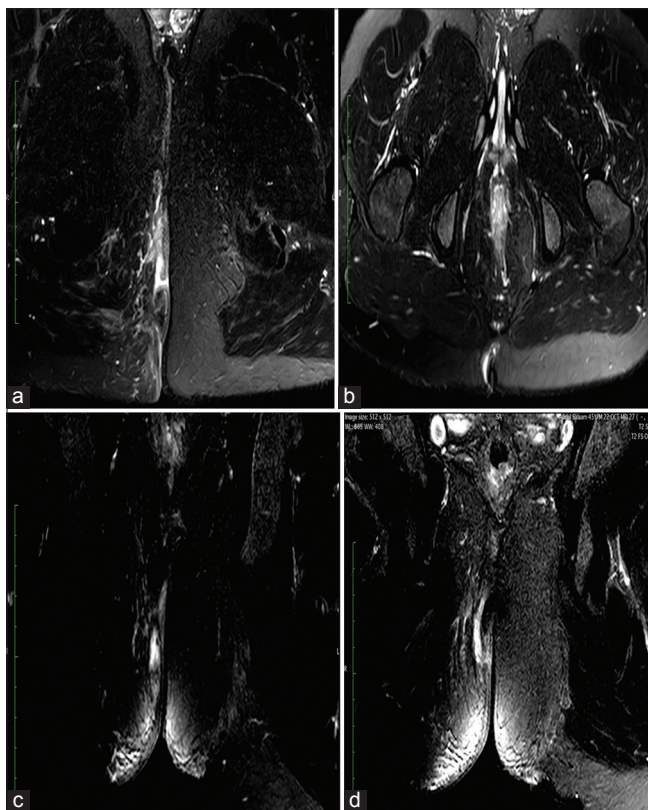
Series of T2 fat-sat axial and coronal images (a-d) showing case of intersphincteric fistula, magnetic resonance imaging Grade I
